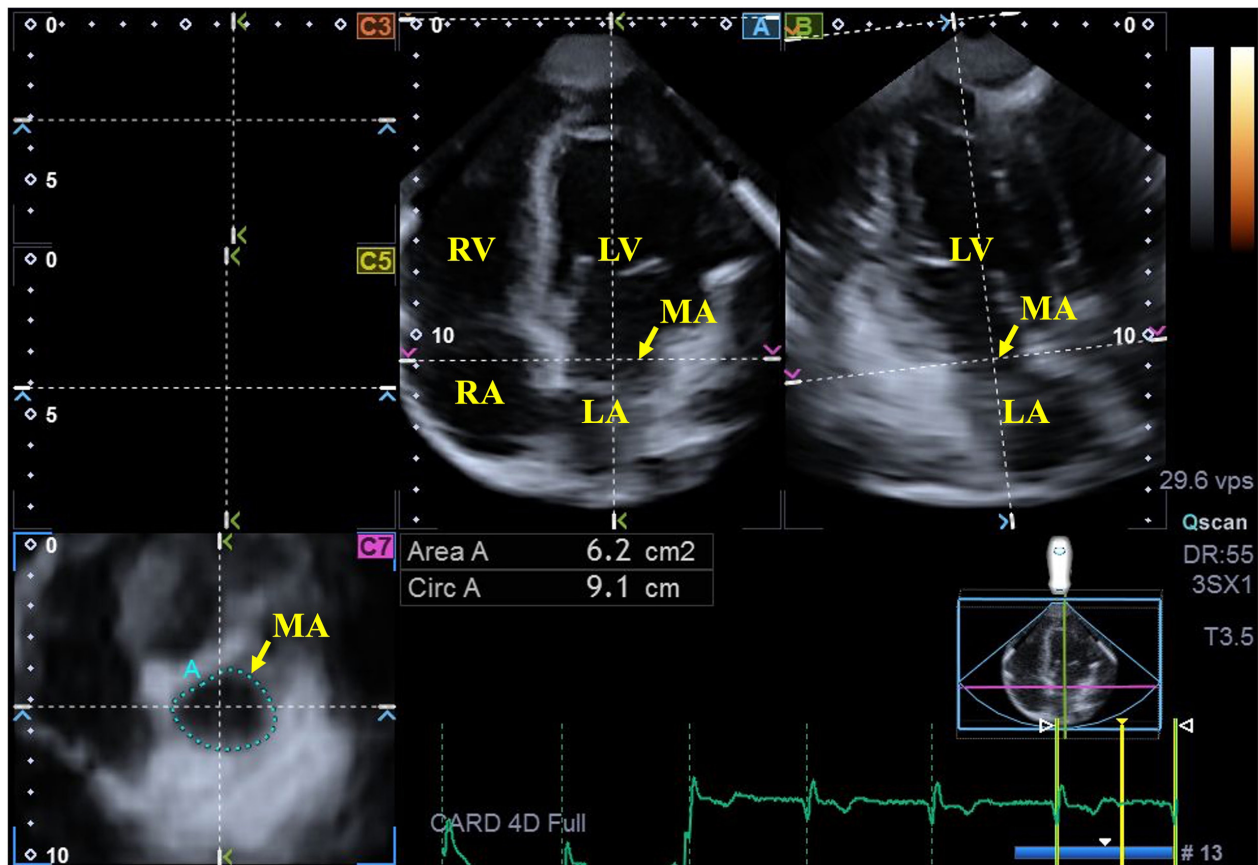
Assessment of mitral annular dimensions by three-dimensional speckle-tracking echocardiography in apical 4-chamber (A) and 2-chamber (B) long-axis views and in a short-axis view (C7) at the level of the mitral annulus in a representative case. LV, left ventricle; RA, right atrium; LA, left atrium; RV, right ventricle; Circ, perimeter; TA, tricuspid annulus; MA, mitral annulus.
